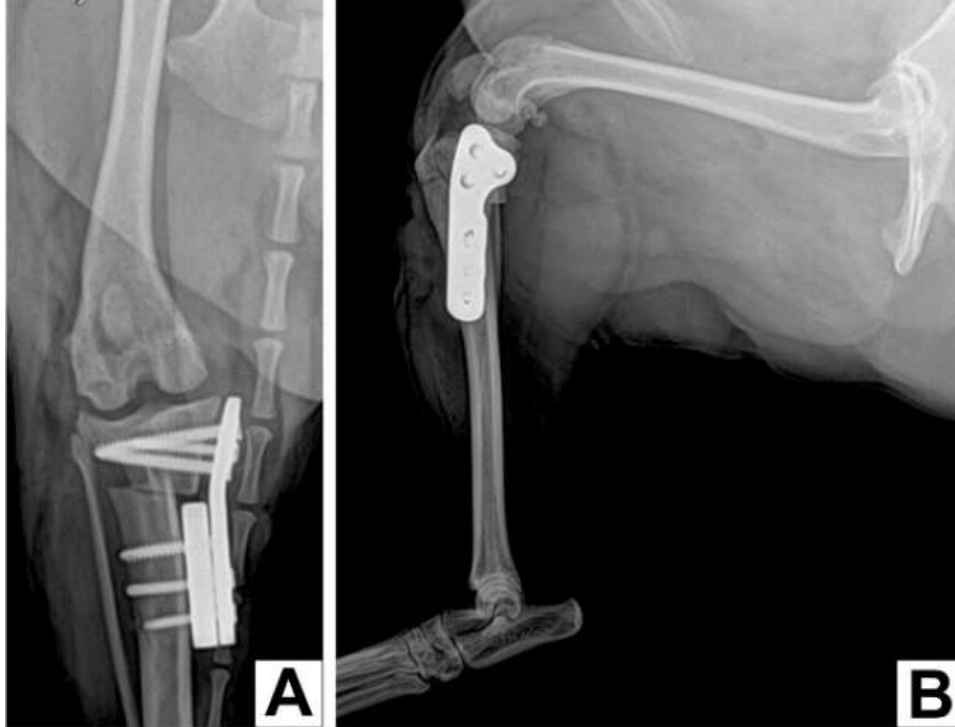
Immediate Post-operative Radiographs.
